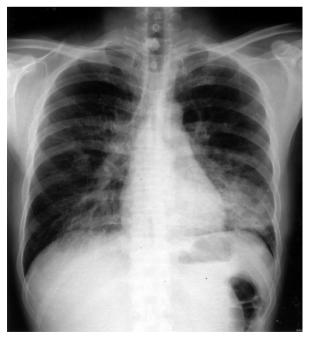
Initial chest X-ray revealed infiltrates at bilateral lower lung fields.
